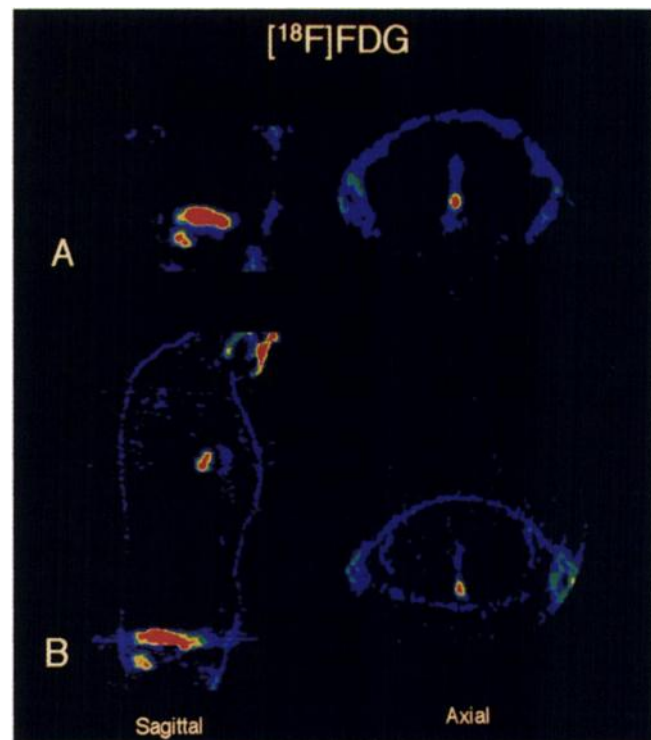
This 60-y-old man had colorectal cancer that was treated surgically and by radiotherapy. CT, performed after CEA increase, shows residual tissue of uncertain nature in site of treatment. FDG studies performed by DH-PET (A) and Ring-PET (B) clearly identify elevated FDG uptake within lesion, confirming presence of recurrence.
